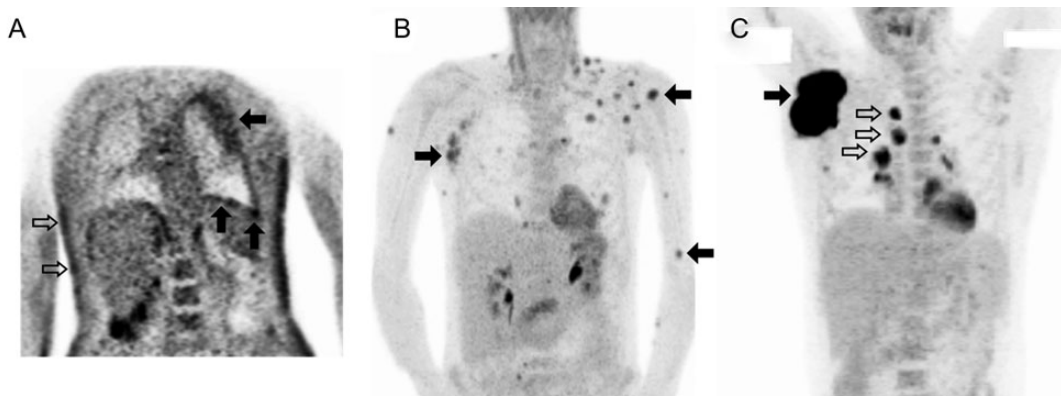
Findings of ^{18}F -fluorodeoxyglucose (^{18}F -FDG) positron emission tomography (PET) in patients with intercurrent tumors, including primary effusion lymphoma (PEL), diffuse large B-cell lymphoma, and Kaposi sarcoma (KS). Representative ^{18}F -FDG PET maximum intensity projections from 3 patients with KS herpesvirus-associated multicentric Castlemann disease (KSHV-MCD) and intercurrent tumors, including large-cell lymphomas and KS. *A*, In a patient with KSHV-MCD and PEL of both pleural cavities and severe cutaneous KS, the pleural surface demonstrates moderately increased avidity throughout, with patches of intense uptake (*closed arrows*; pleural nodal maximal standardized uptake value [SUV_{max}], 7.0), whereas the lymphomatous effusion (*above lower closed arrows*) is not ^{18}F -FDG avid. Areas of moderate hypermetabolic activity are also seen in the skin at sites of KS involvement (*open arrows*). Lymph nodes and spleen were metabolically normal. The acquired imaging field and image quality in this patient was reduced owing to his critical illness. *B*, In a patient with KSHV-MCD and extracavitary PEL presenting with cutaneous and soft tissue, marked areas of avidity are seen at the sites of extracavitary PEL (*closed arrows*; lesion SUV_{max} , 11.0), while nodes are normal; the patient had previously undergone a splenectomy. *C*, In a patient with KSHV-MCD and diffuse large B-cell lymphoma, intense avidity is seen at the primary lymphomatous mass (*closed arrow*; SUV_{max} , 38.2) and less intense avidity at nearby involved nodes (*open arrows*), whereas uninvolved nodes and spleen are normal. Normal cardiac uptake is seen in *B* and *C*, and normal tracer excretion into the renal collecting system in *B*.
